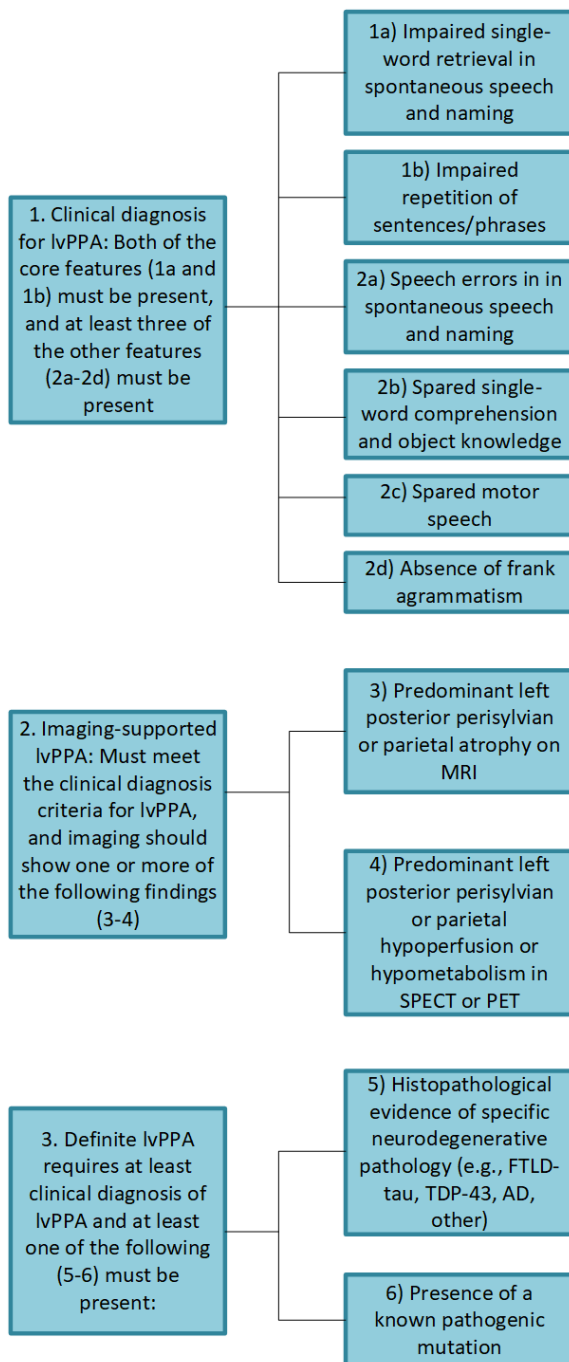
Diagnostic criteria for lvPPA according to Gorno-Tempini et al. 2011. LvPPA = logopenic variant of primary progressive aphasia, MRI = magnetic resonance imaging, SPECT = single photon emission computed tomography, PET = positron emission tomography, FTLDTau = frontotemporal lobar degeneration, TDP-43 = TAR-DNA binding protein of 43 kDa, AD = Alzheimer`s disease.
